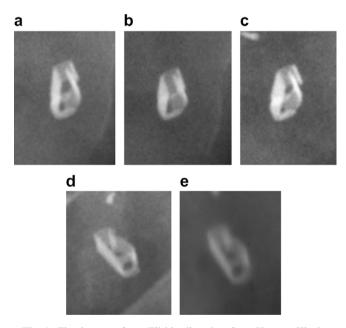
Five images of one Filshie clip taken from X-rays (Clip 2).
